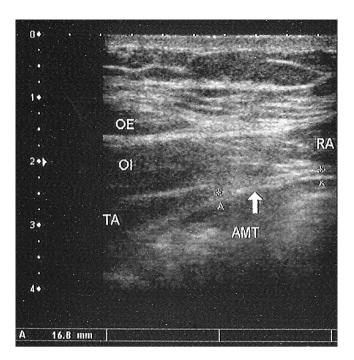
Ultrasonographic image of the aponeurosis of the transversus abdominis muscle above the arcuate line. OE (external oblique), OI (internal oblique), TA (transversus abdominis) and RA (rectus abdominis) represent the muscles studied. AMT: aponeurosis of the transversus abdominis muscle above the arcuate line, in this image measuring 1.68 cm
